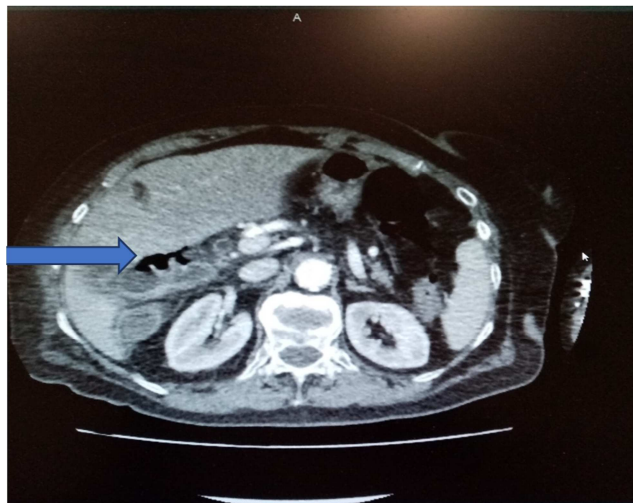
Axial cross-sectional abdominal CT scan showing air bubbles in the vesicular wall.
